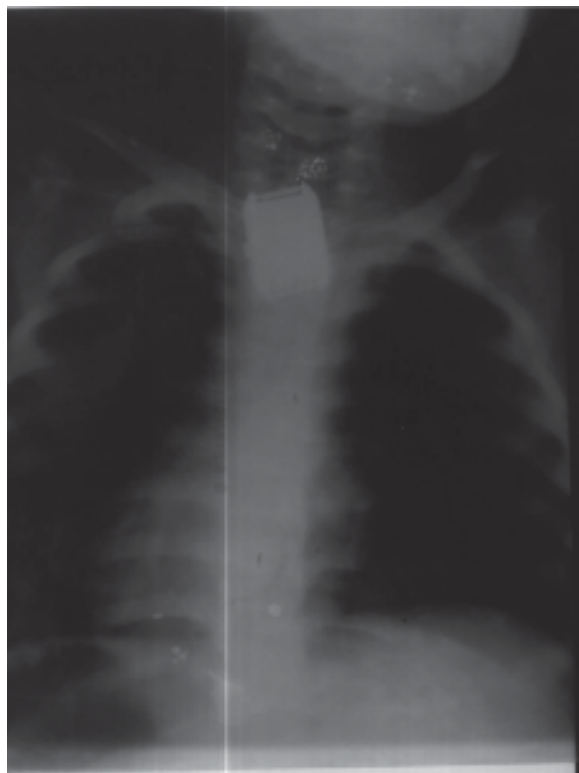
X-ray Neck P/A view showing wrist watch, upper end of esophagus
